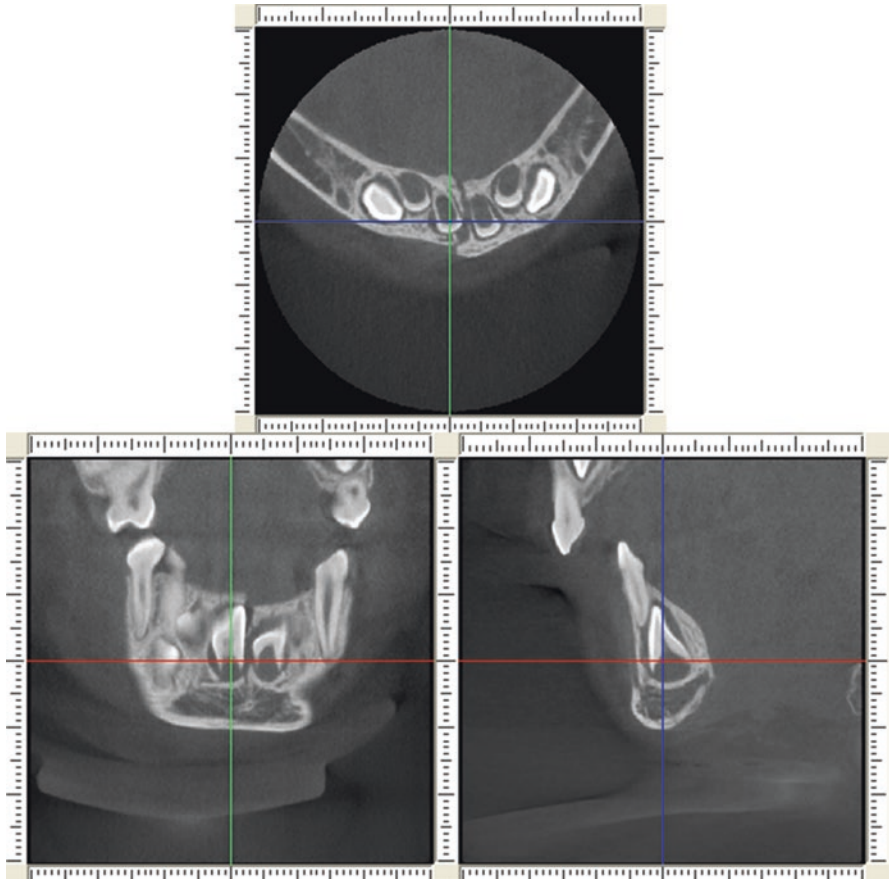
This is a small-field-of-view cone beam computed tomography of a 4-year-old child with a mandibular symphysis fracture. The axial slice shows nicely how the fracture line meanders between the tooth germs of the permanent central incisors. In the coronal view one can appreciate the step in the alveolar crest, with the patient's mandibular body on the left-hand side being a little more inferior than that on the right-hand side. One can debate if this was an accident or child abuse (courtesy of Prof. Dr. Edgar Hirsch, Germany)
